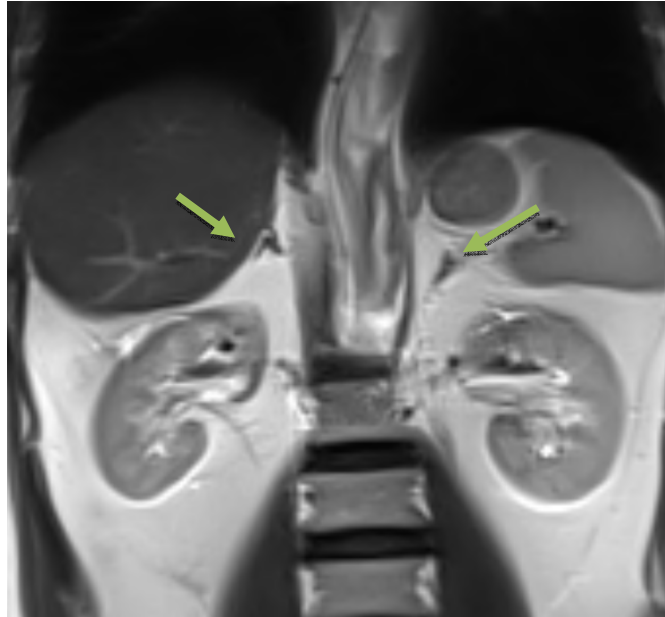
MRI of adrenal gland
